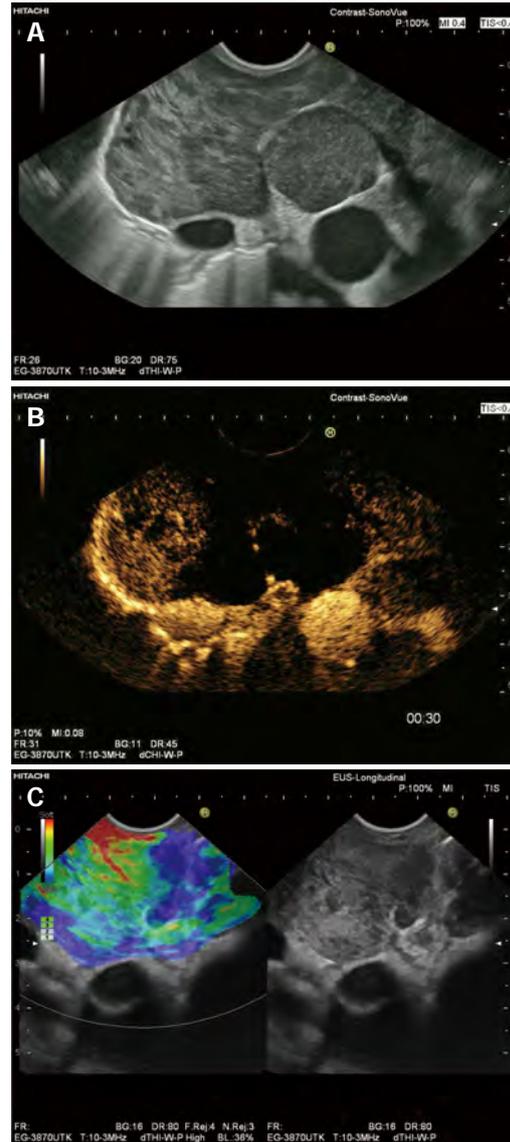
Endosonography of enlarged subcarinal lymph nodes in Non-Hodgkin Lymphoma. A: B-mode reveals two enlarged lymph nodes; B: contrast enhanced endoscopic ultrasound demonstrates extensive avascular (necrotic) areas in the lymph nodes; C: real time endoscopic elastography indicates hard, infiltrated areas (blue color), thus targeting endoscopic ultrasound-guided biopsy.
